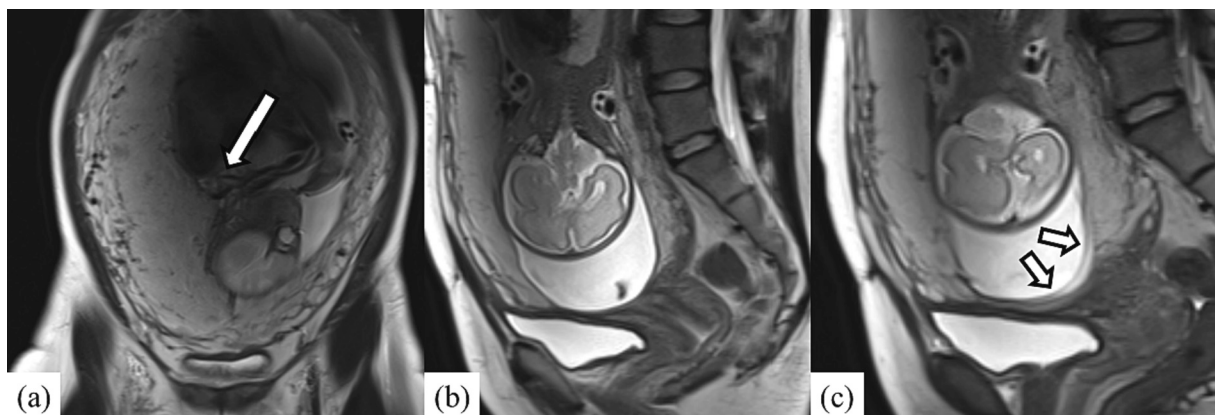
Magnetic resonance imaging performed at 27 weeks and 3 days. (a) Normal cord insertion at the upper uterine segment is shown in the coronal section. (b) The vessels of vasa previa are not visible in cross-sections where the cervical gland is visible in the sagittal section. (c) The sagittal image slightly deviated cross-section from image (b) shows one vessel of vasa previa.
